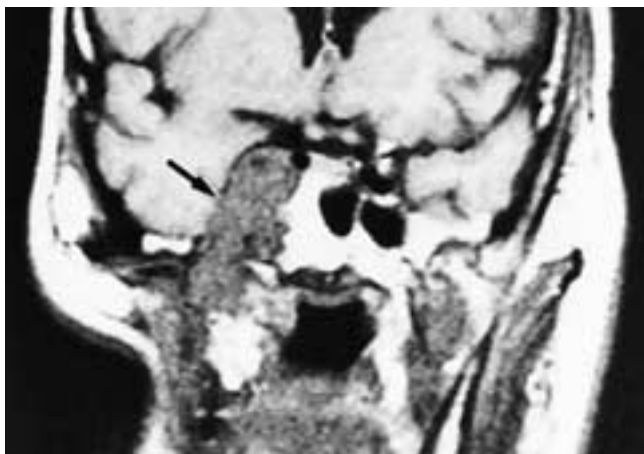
Coronal T1-weighted MR image of a patient who previously had had a right parotidectomy. The recurrent tumor has grown from the parotid bed up along the auriculotemporal nerve to the third division of the trigeminal nerve and then via the foramen ovale it invades the right cavernous sinus (arrow). This patient had recurrent AdCC. (From Som PM, Braun IF, Shapiro MD, et al. Tumors of the parapharyngeal space and upper neck: MR imaging characteristics. *Radiology* 1987;164: 823–829.)
